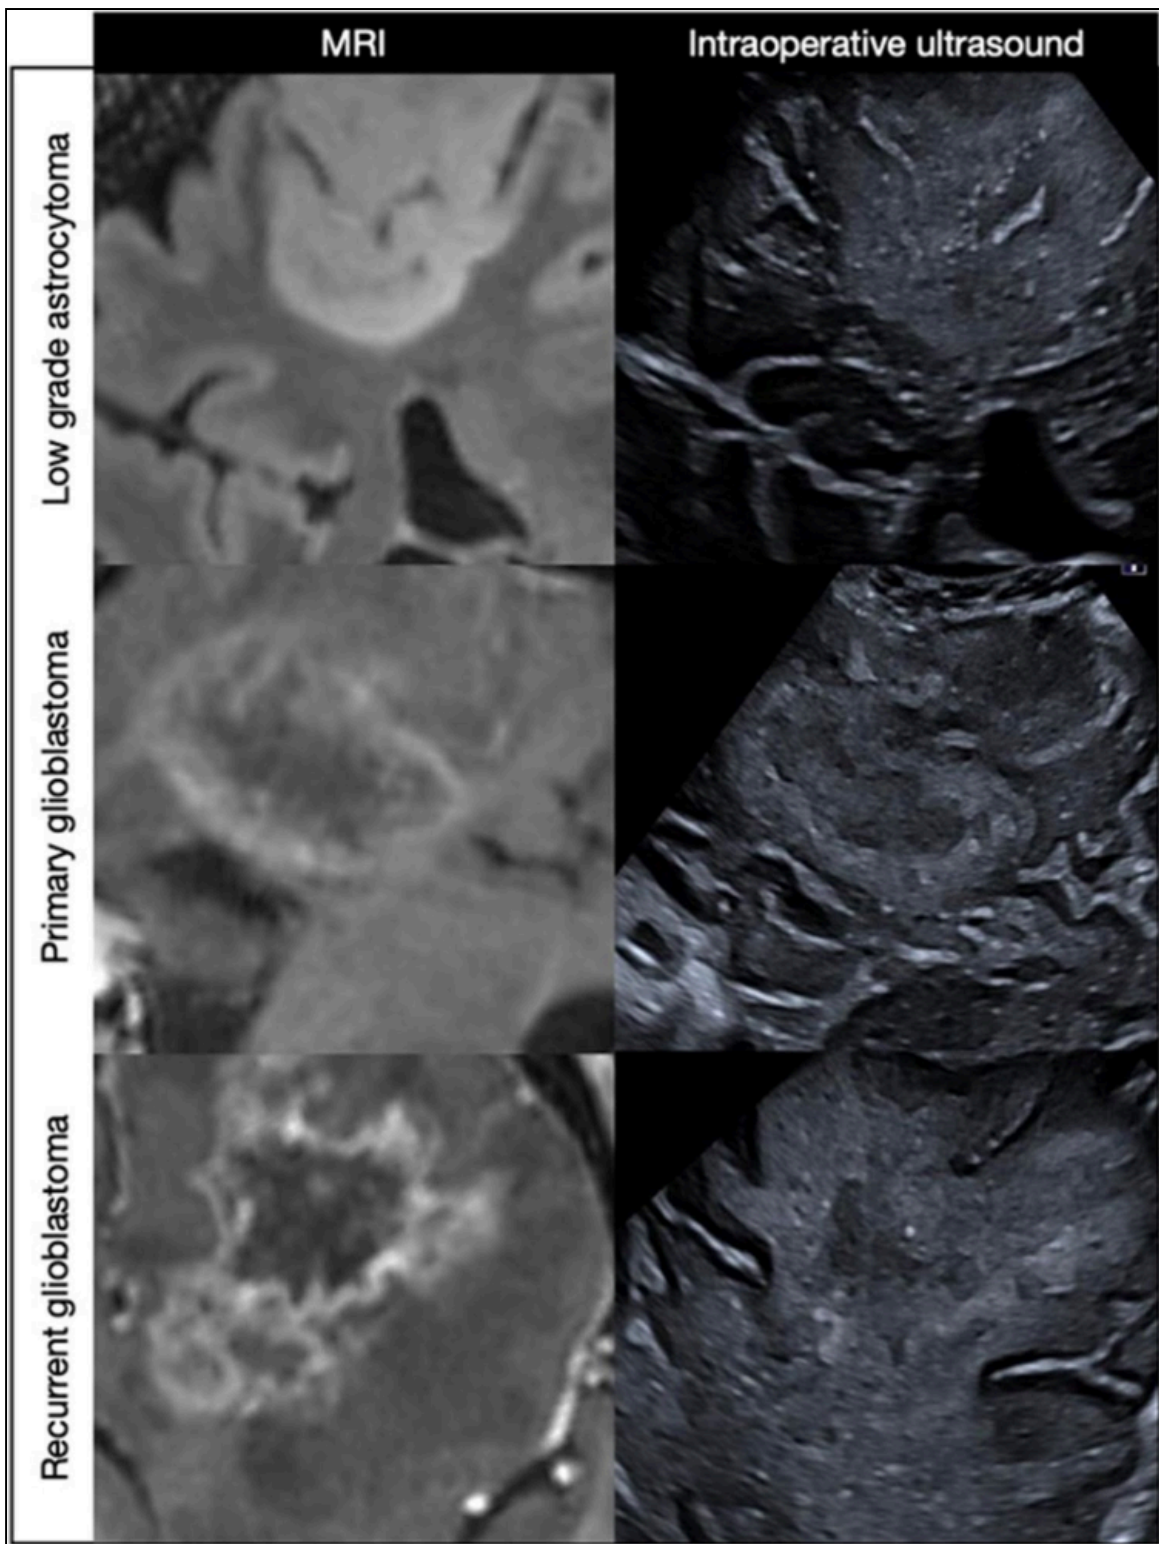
Three tumor types – MRI vs US comparison. Primary GBM has clear boundaries, LGG is fair, recurrent GBM is nearly invisible on US
